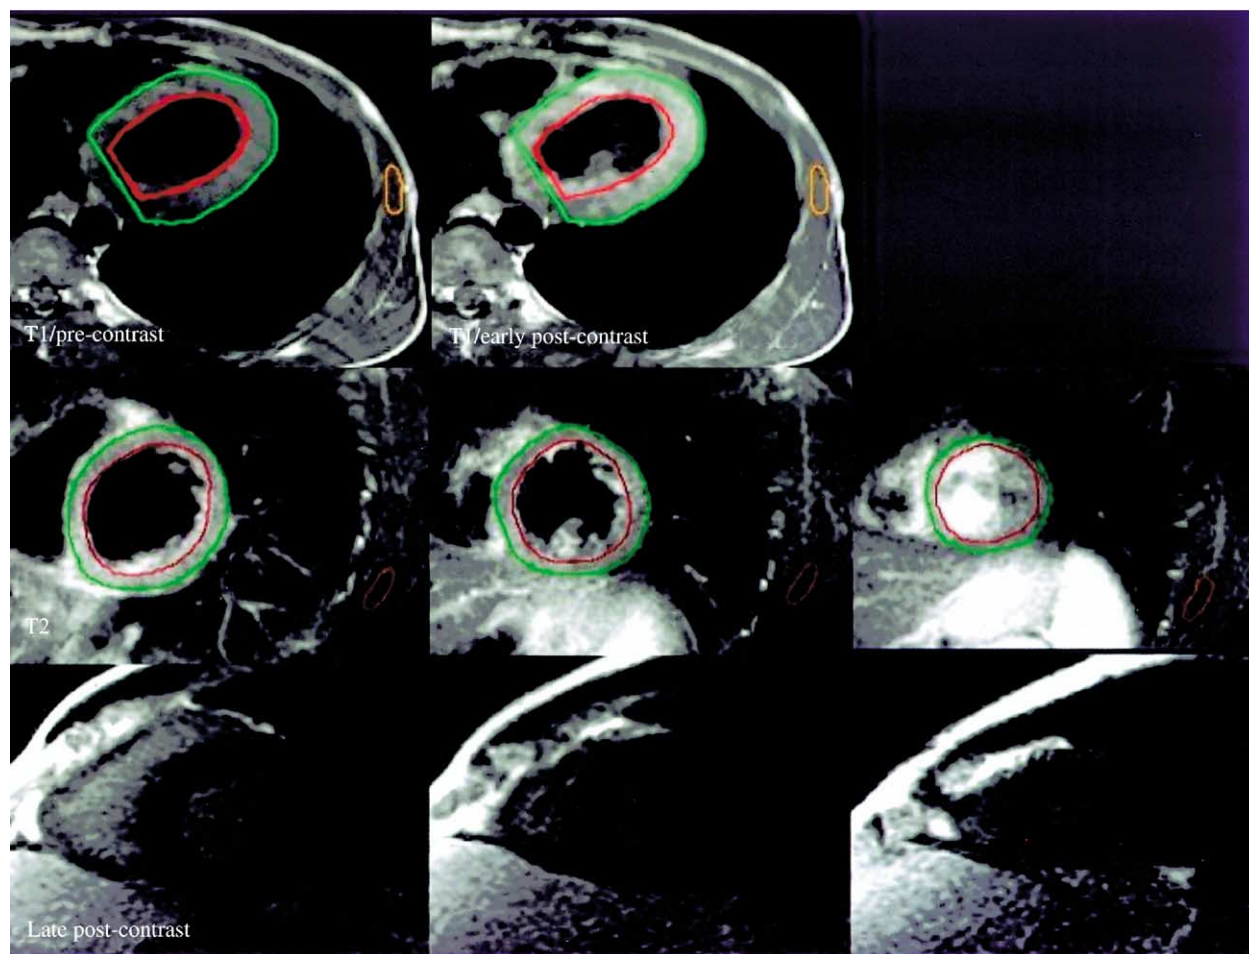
Cardiovascular magnetic resonance images from Patient #6. (Top) Pre- and postcontrast axial T1-weighted spin echo images of the same slice. Global relative enhancement was elevated (4.6). Regions of interest are drawn around the myocardium and within the skeletal muscle. (Middle) Short-axis T2-weighted images: no focal areas of high T2 signal, yet the higher global myocardial T2 signal in relation to the skeletal muscle is visibly appreciable (exact value = 2.5). (Bottom) Corresponding late enhancement images: no evidence of late gadolinium enhancement.
